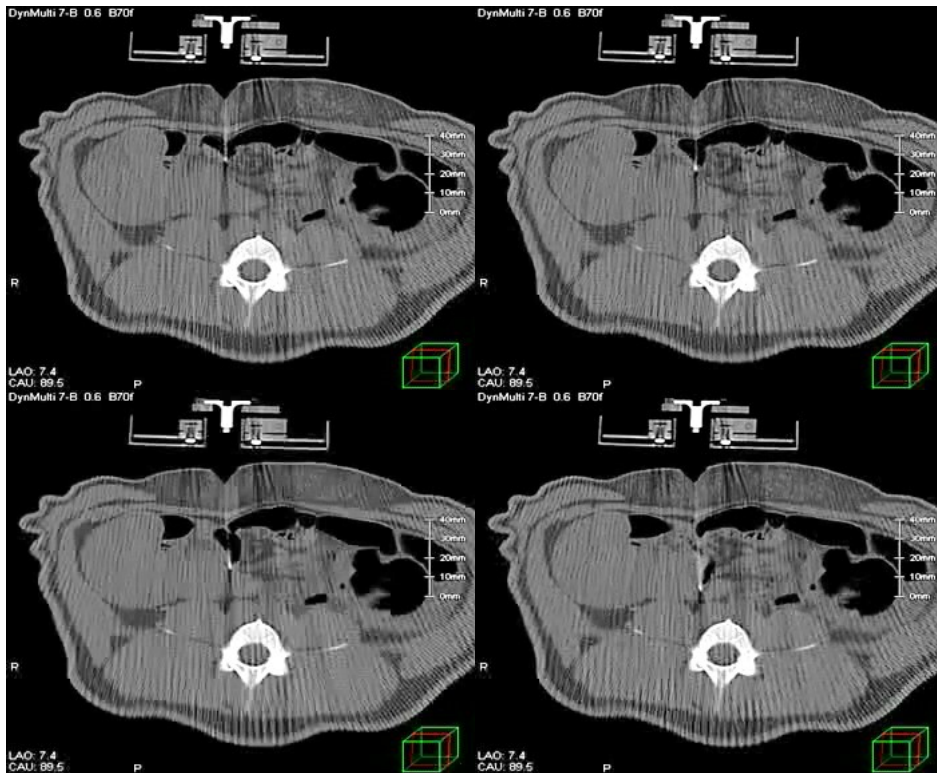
The sequential CT images tracking the needle in No. 7 insertion path
